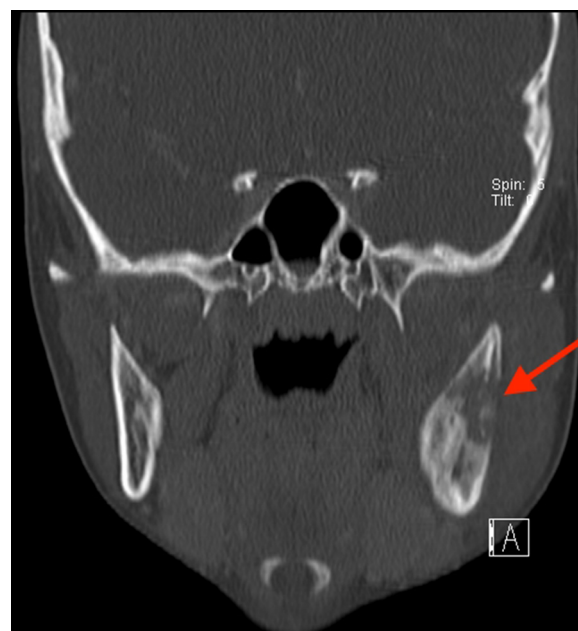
The CT coronal view of the mandibular lesion.
